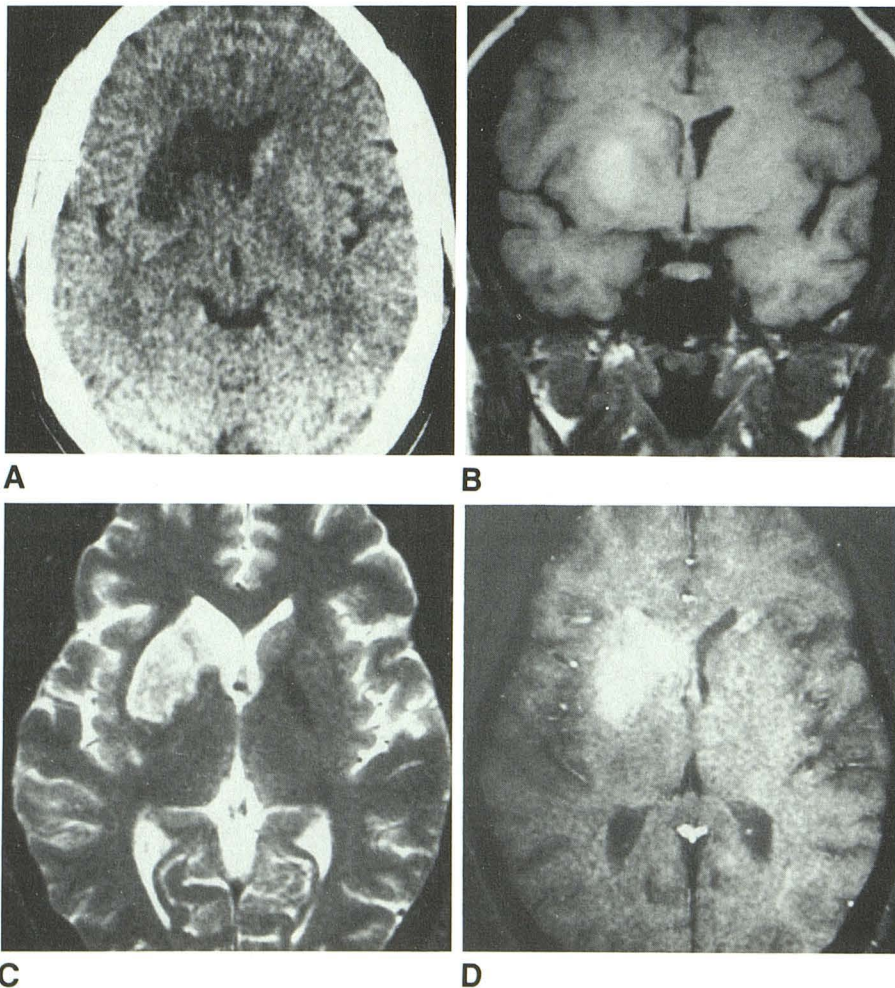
Infarct in right basal ganglia shows hemorrhage on MR but not on CT on day 1.
